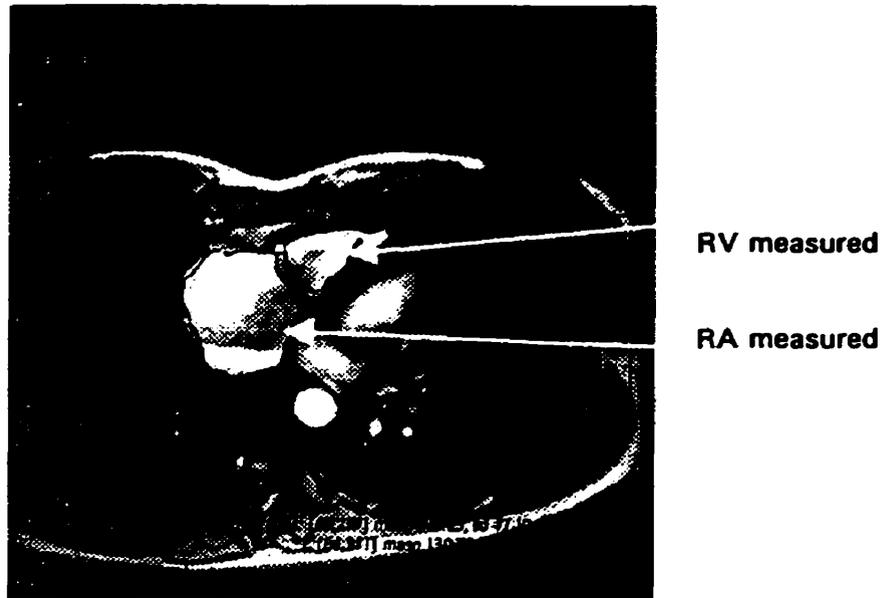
MRI image of one slice at end ventricular systole. The volume areas are traced by hand and the software calculates the enclosed area.
